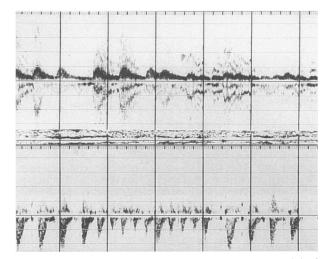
A pulsed Doppler interrogation within the umbilical artery (top) and the pulmonary artery (bottom) is shown taken of a fetus with supraventricular tachycardia. The reduction in stroke volume during tachycardia, followed by a pause and resumption of normal sinus rhythm, is clearly seen in the lower panel. Horizontal lines represent Doppler velocities of 0.25 per millisecond; vertical lines are time markers (1 sec) (from Schmidt and Silverman<sup>48</sup>).
